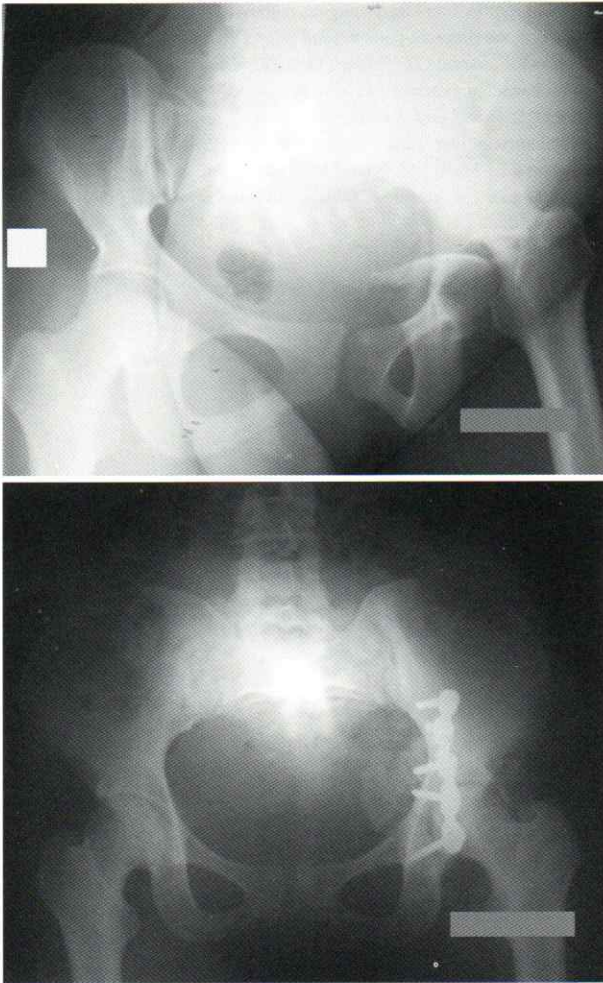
Patient 2 (a) Radiographs showing comminuted transverse and posterior wall acetabular fracture with an iliac dislocation of the femoral head, foetus in breech presentation (b) X-ray 3 months after surgery showing ossifications
